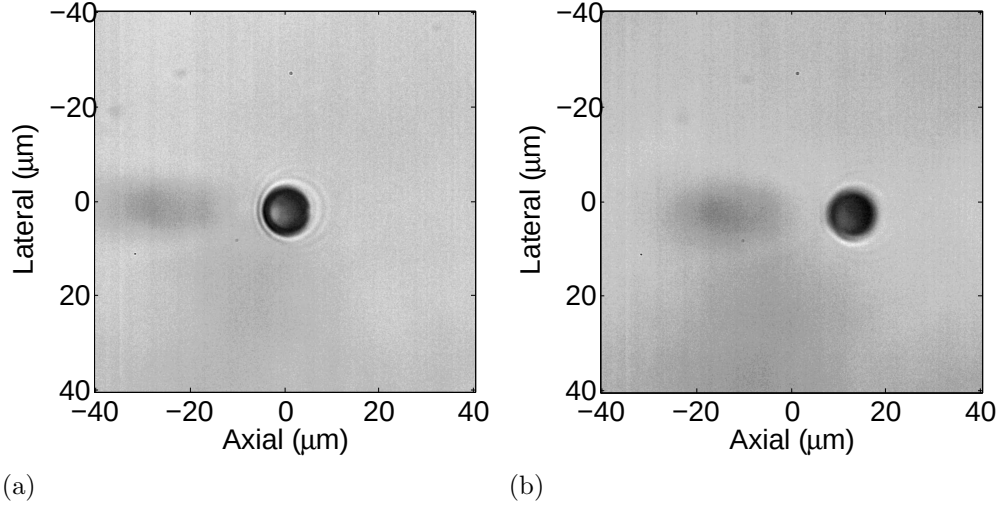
Representative high-speed camera images captured (a) before and (b) during ultrasound excitation. The focal point of the ultrasound field is in the middle of the image.
